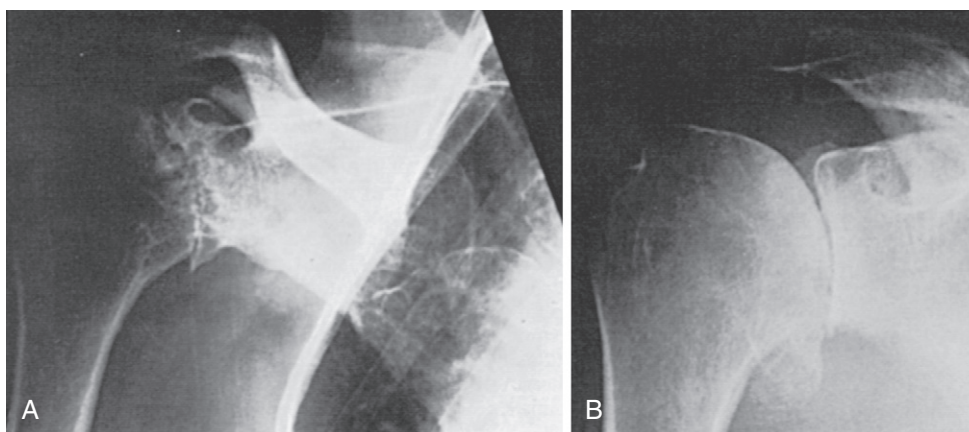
Plain radiographs. A, Rheumatoid arthritis with loss of joint space, cyst formation, glenohumeral erosion, and early proximal subluxation of the humerus, indicating a rotator cuff tear. B, Osteoarthritis with narrowing of the glenohumeral joint space, sclerosis, and osteophyte formation. Notice the preservation of the subacromial space, suggesting an intact rotator cuff.
